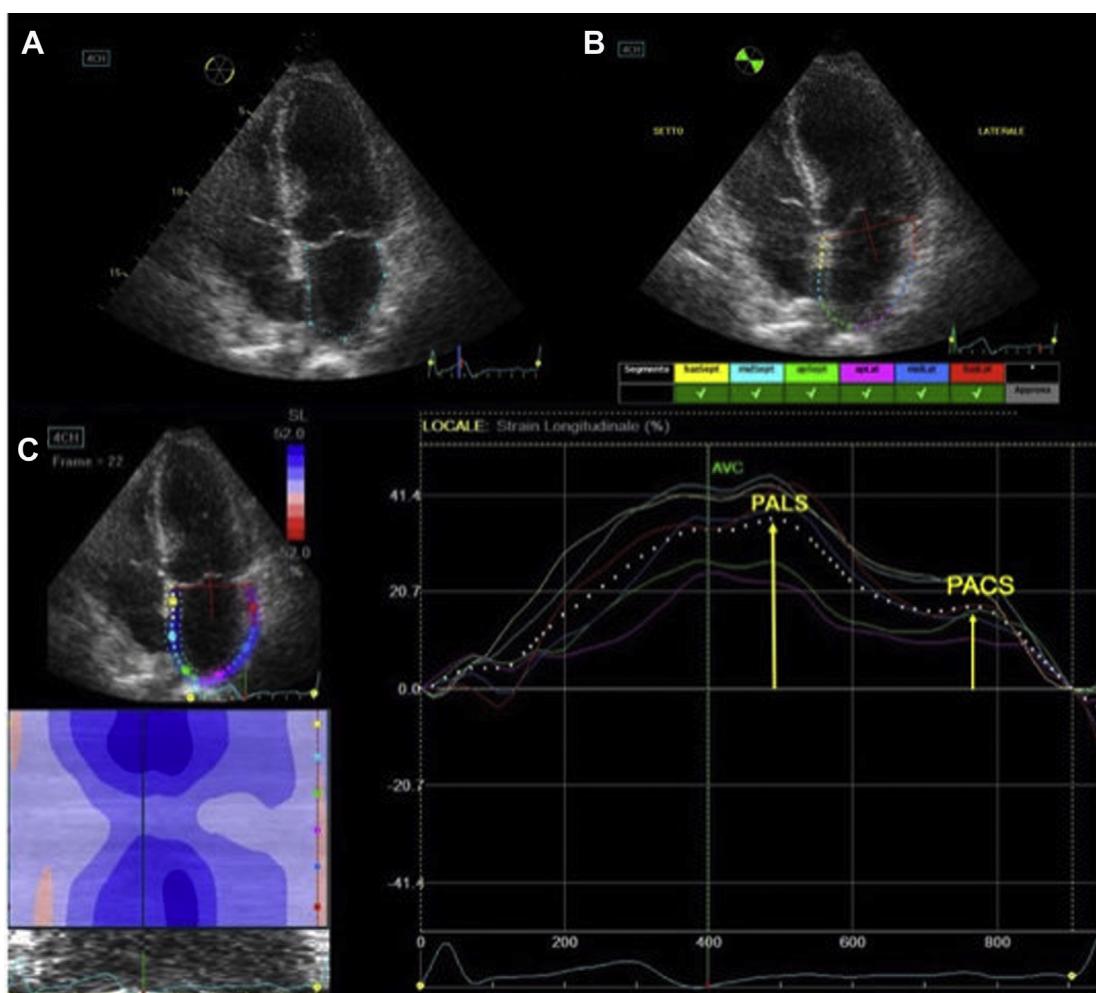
Comprehensive LA function by 2D longitudinal strain from an apical 4-chamber view. (A) LA endocardial region of interest tracing. (B) The LA is divided into 6 segments: basal septal (basSept; yellow), midseptal (midSept; light blue), apical septal (apSept; green), apical lateral (apLat; lilac), mid lateral (midLat; blue), and basal lateral (basLat; red). (C) Strain curves during a cardiac cycle using the onset of the QRS complex as the starting point. Each curve represents one LA segment. An average atrial longitudinal strain along the cardiac cycle is depicted (dashed curve). AVC, aortic valve closure; PACS, peak atrial contraction strain; PALS, peak atrial longitudinal strain.
